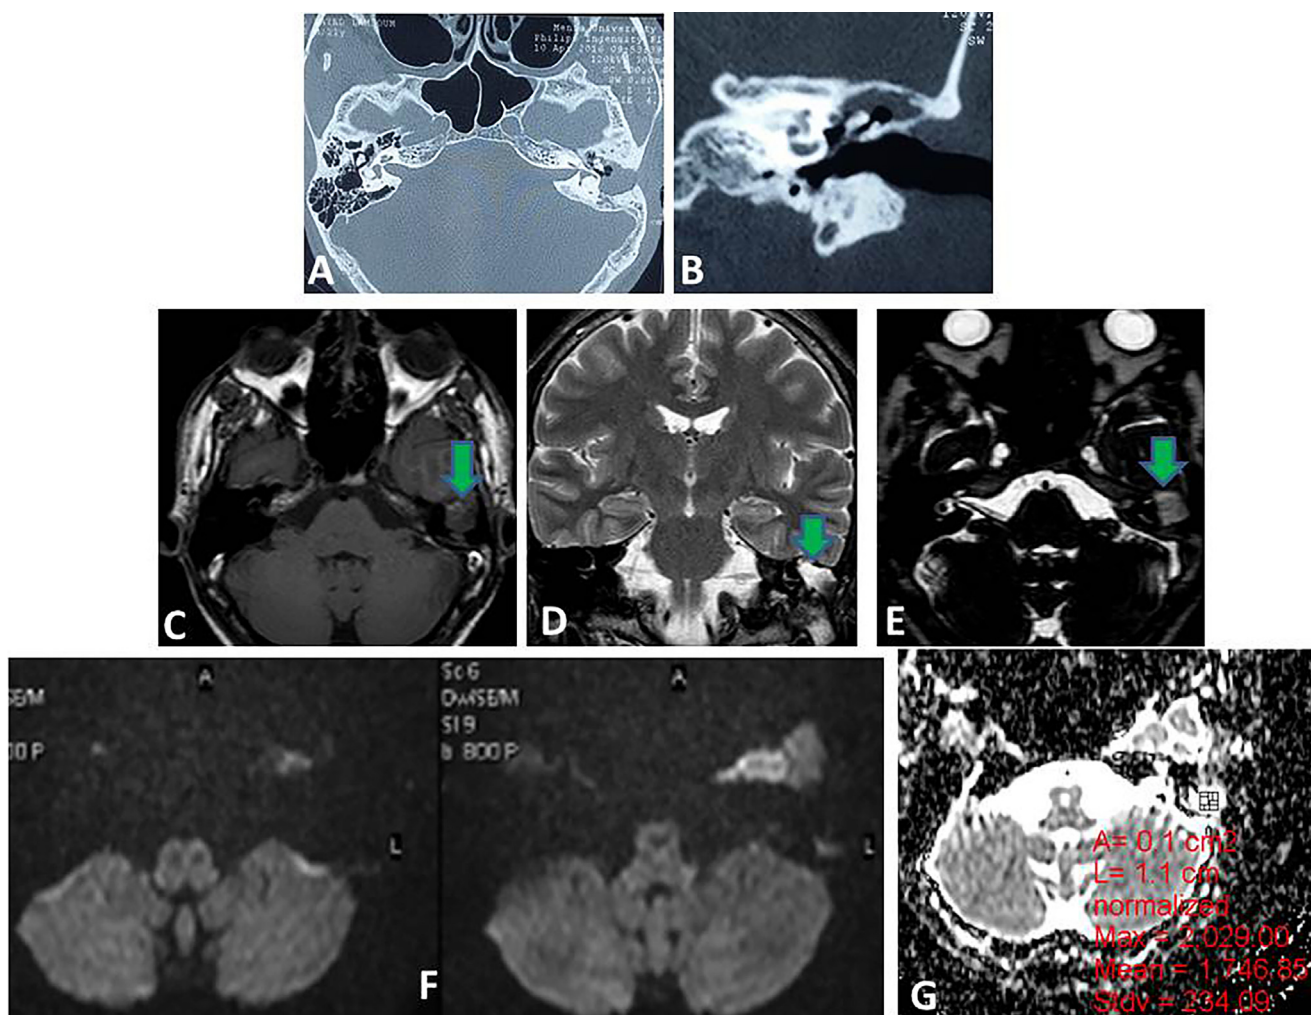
Left CSOM without cholesteatoma in of a 21 years old man who underwent left CWU middle ear surgery. (A and B) Axial and coronal CT cuts showed complete opacification of the left middle ear cleft by tissue density lesion associated with intact ossicular chain. (C) Axial T1WI, (D) Coronal T2WI, and (E) Axial CISS showed a soft tissue density lesion in the left middle ear cleft of low signal in T1WI and high signal intensity in T2WI and CISS (green arrows). (F) Axial DWI obtained with a b factor of 1000 s/mm² showed no high signal intensity at the left middle ear cleft. (G) ADC (mean $1.746.85 \times 10^{-3}$ mm²/s).
